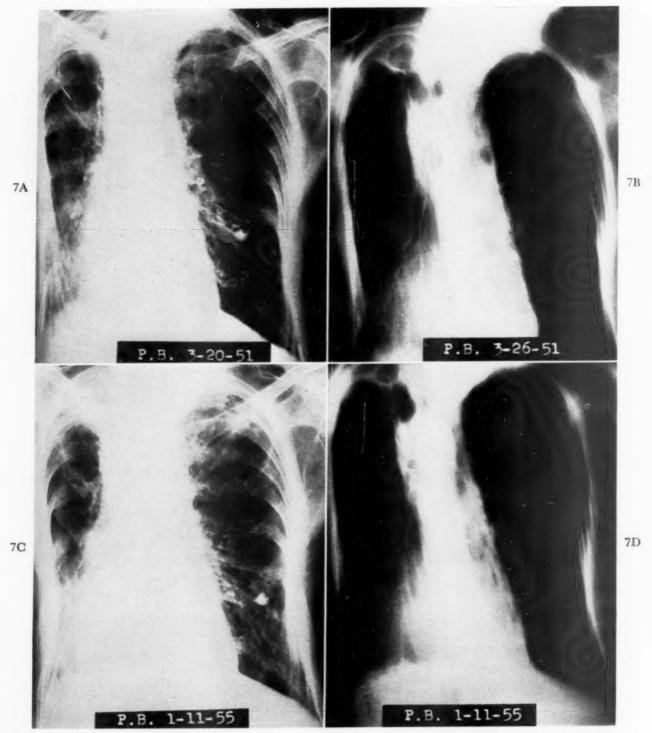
Case III. A through D, chest roentgenograms taken approximately four years apart showing the static appearance of the left apical lesion with cavity. Note the thin rim of calcium deposit lining the cavity and calcification in the right lung field.
